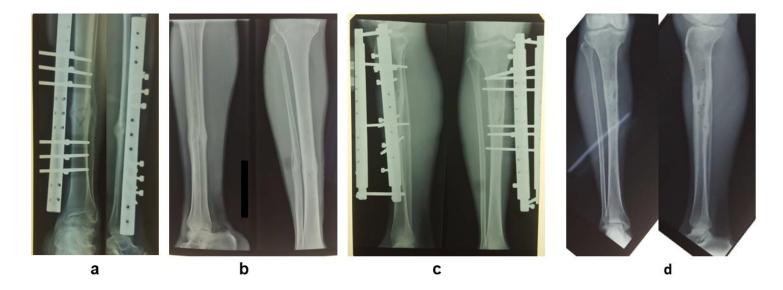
Radiographs at 6 months after the initial operation (a,c) and at final follow-up after LDEF removal (b,d)
